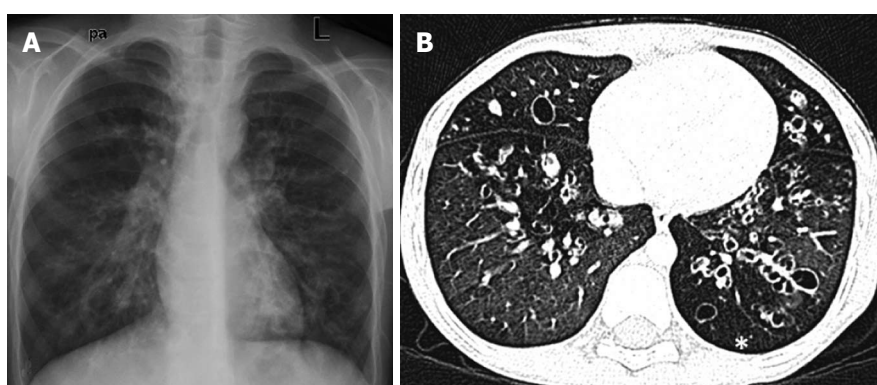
A 10-year-old boy with post-infectious bronchiectasis. Frontal chest radiograph (A) showing multiple cystic lucencies and tubular opacities in both lungs. Chest high resolution CT image (B) shows multiple areas of cystic bronchiectasis with associated air trapping (asterisk).
